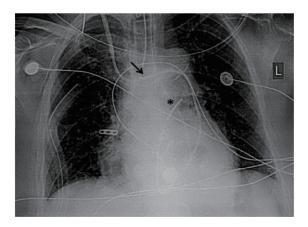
Chest X-Ray demonstrating Swan-Ganz catheter crossing midline. Black arrow notes a catheter crossing through a bridging vein, asterisk points at the tip of the catheter ending in the left pulmonary artery.
